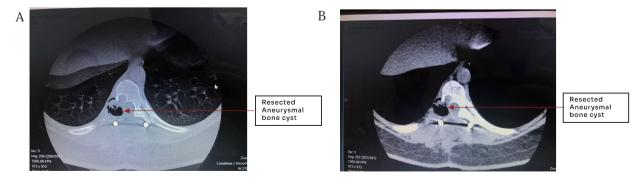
Computed Tomography of the Dorsal Spine reveals lesion and tumor resection. A) Significant resection of the lesion and soft tissues in T9 on the right. B) Bone window with satisfactory tumor resection on the right in D9.
